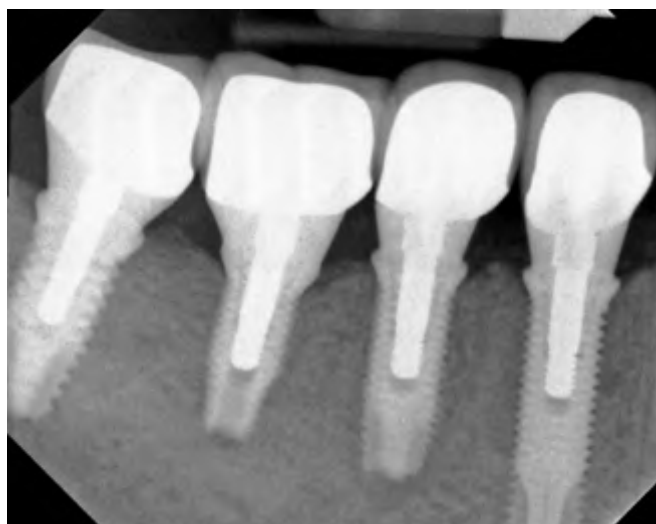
Radiograph with the individual implant crowns on their respective four abutments in place demonstrated that the crowns were seated properly onto the abutments. An ill-fitting crown would be identified by a radiolucent space between a crown and an abutment.
